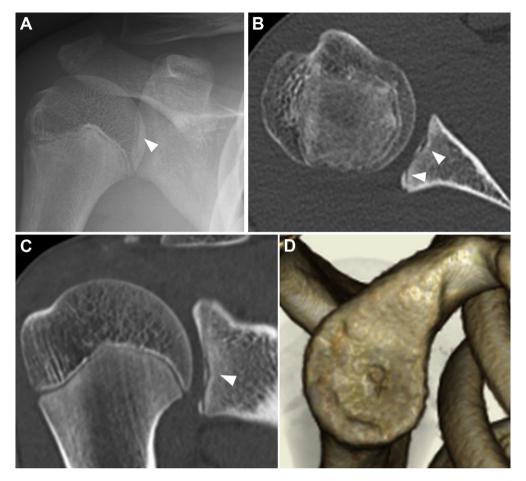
Anteroposterior radiograph (A) and computed tomography (B, C, D) of the right shoulder showed a radiolucent lesion (arrowheads) on the surface of the glenoid.
